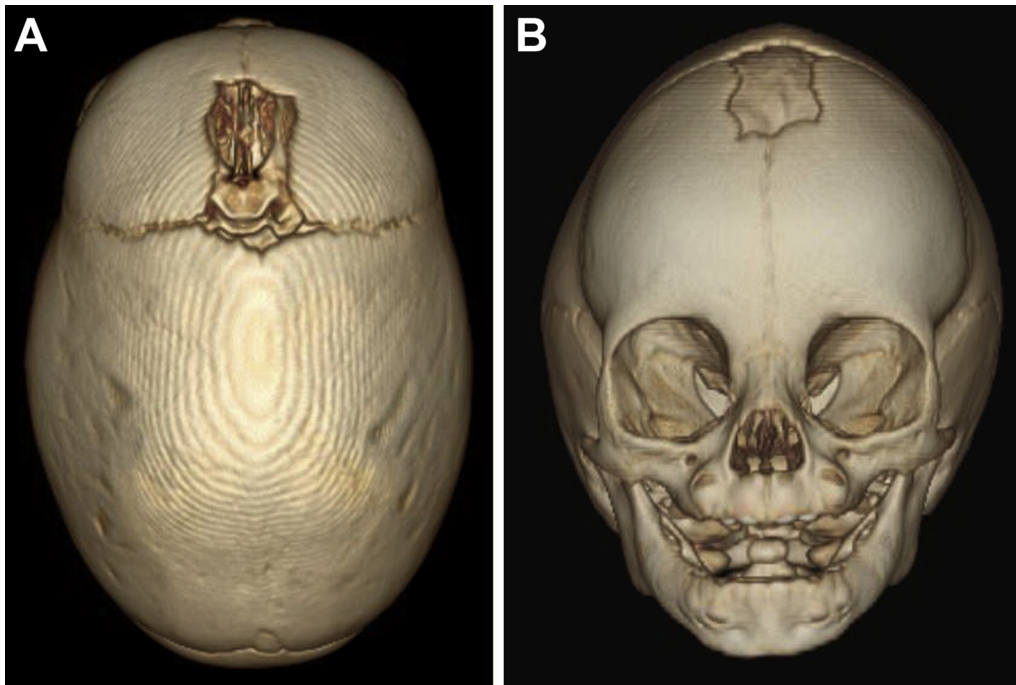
Sagittal craniosynostosis. Top (A) and front (B) views of a three-dimensional computed tomography scan showing a skull long on the anteroposterior axis and narrow on the transverse axis. The sagittal suture is closed; the anterior fontanel is open in this case. (The color version of this figure is available in the online edition.)
